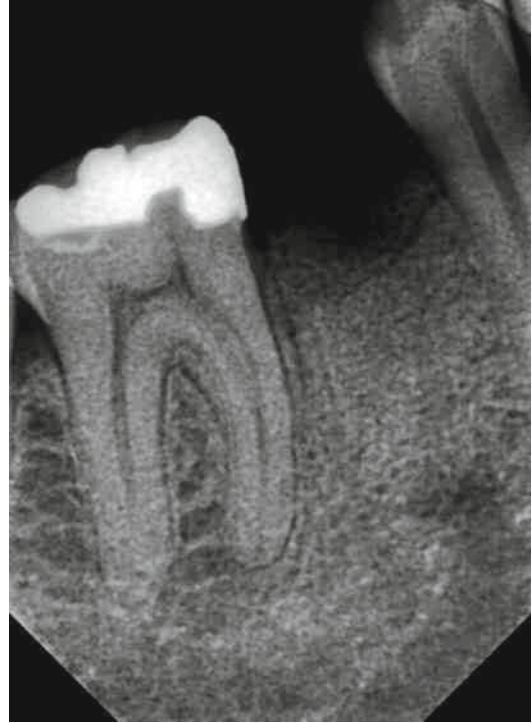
Periapical radiograph taken immediately after socket preservation procedure
